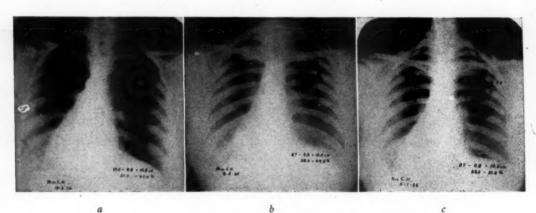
a, Moderate cardiac enlargement in middle aged female. Rheumatic mitral insufficiency with decompensation. Occasional dyspnea since rheumatism at 14. Precordial pain, increased dyspnea, nausea and vomiting of 5 months' duration. Surgeons refused to operate for uterine fibroids because of condition of heart. P. M. I. palpable at that time 14.0 cm. to left of median line. Evident wide dilatation present. Plate taken 2 months after entrance to hospital when patient had gained sufficient strength to undergo x-ray.
